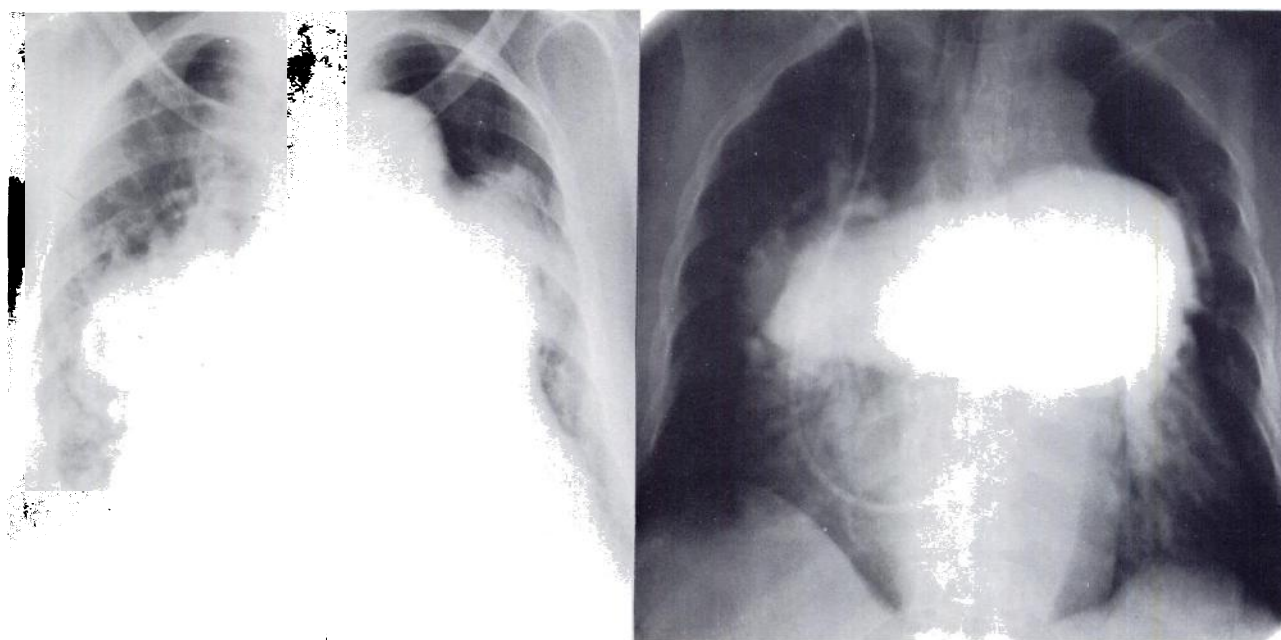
(Case 1), left. Chest roentgenogram depicting cardiomegaly and bilateral hilar masses. FIGURE 2 (Case 1), right. Angiogram demonstrating enormously dilated major pulmonary arteries.
